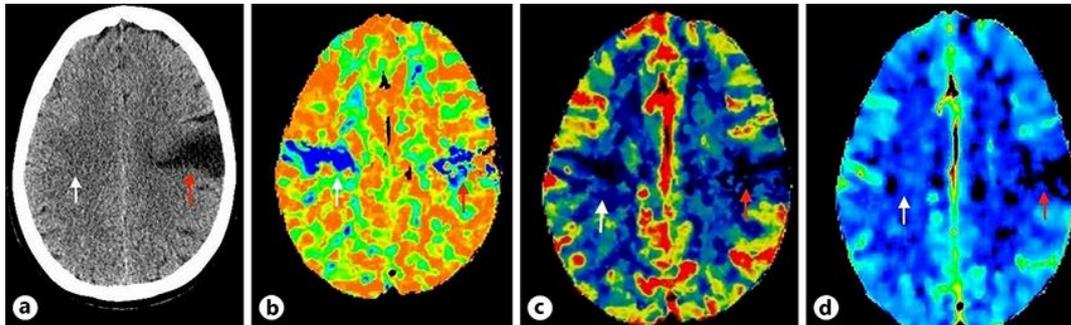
a CT without contrast showing substance loss in the left frontal operculum due to a previous ischemic infarct (red arrow) with no visible infarct in the right opercular region (white arrow). b CT mean transit time showing elevated transit time in the right opercular region (white arrow) and in the left opercular region of the old infarction (red arrow). c CT cerebral blood flow (CBF) showing decreased cerebral flow in the right opercular region (white arrow), and in the left opercular region of the old infarction (red arrow). d CT CBF with slightly increased cerebral blood volume in the right frontal operculum (white arrow) compared to the left opercular region of the old infarction (red arrow).
